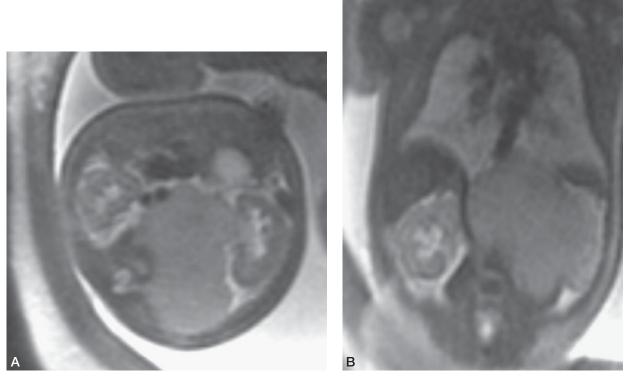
A. Axial image on fetal MRI of a large neuroblastoma arising from the retroperitoneum. B. Coronal image of same fetus demonstrating very large neuroblastoma.
